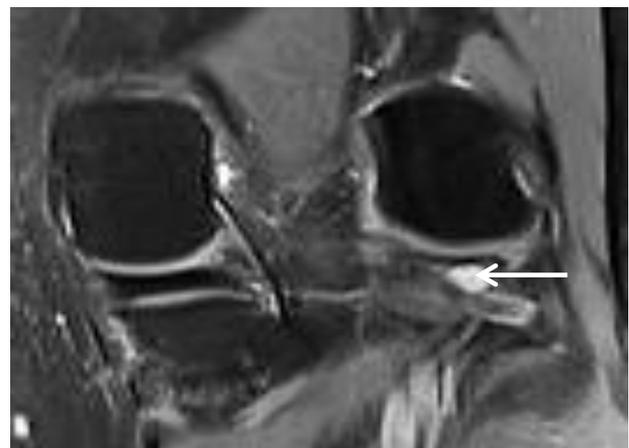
Parameniscal cyst. Coronal T2-weighted FSE fat-suppressed image shows T2 hyperintense fluid collection (arrow) in contact with the lateral meniscus with underlying lateral meniscal tear.
